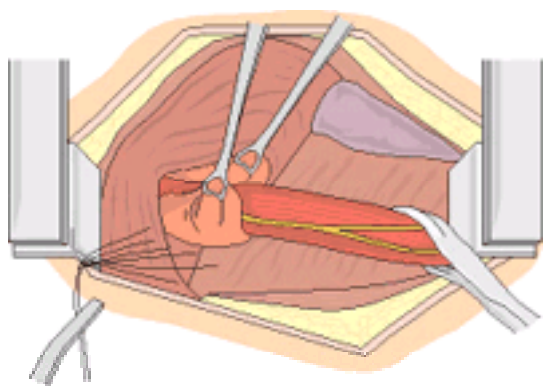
Transthoracic Nissen fundoplication. (3) The posterior and anterior fundic walls are brought through the hiatus into the chest and are plicated around the lower esophagus.
